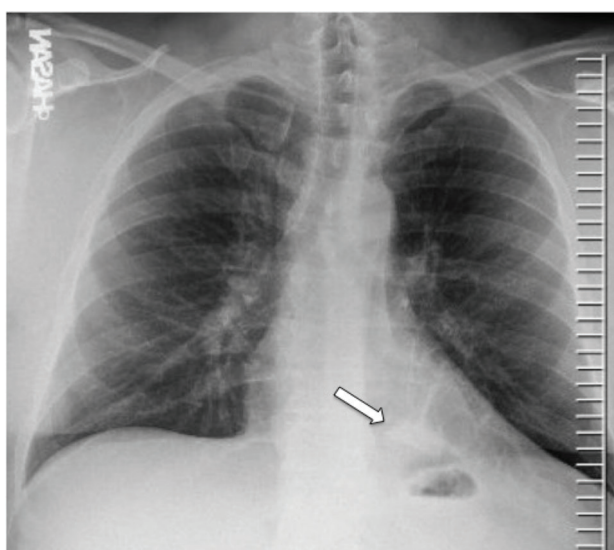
Chest radiograph showing an abnormal opacity on the retrocardiac area of the left hemithorax (Arrow).
